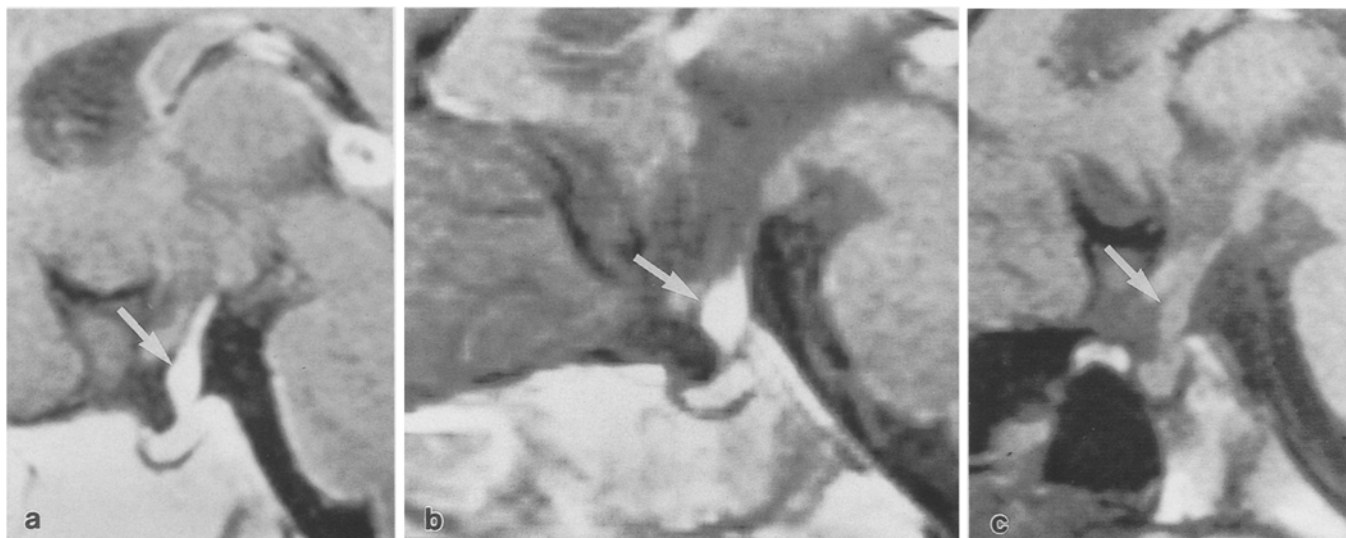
MRI before (c, case 3) and after gadolinium (a, case 1; b, case 2) in three patients with DI and symmetric thickening (3.0 mm, 3.1 mm and 3.5 mm) of the central part of the pituitary stalk (see arrows). Cases 1 and 2 developed typical peripheral lesions of LCH 6 months and 4 months after MRI
